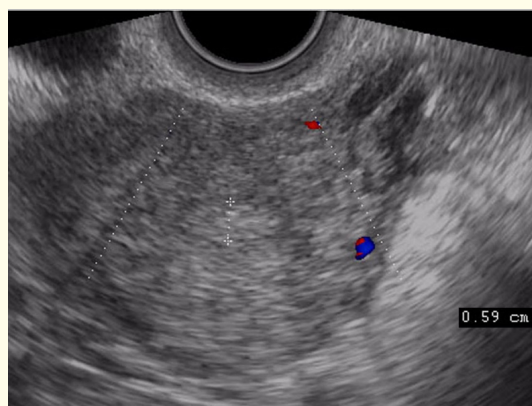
Transvaginal color Doppler endometrium view of a 29-year-old female with LPhD. On the 22th day of the cycle. M-echo is about 6 mm. In the color Doppler mode, there are no vascular signals on the endometrium.
